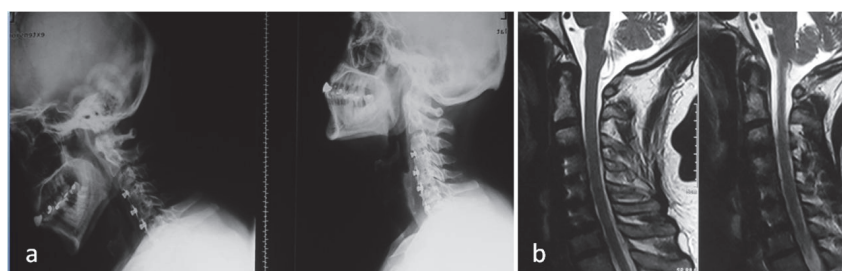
A 60 year-old male patient with 4-level ACDF with PEEK cages with perfect cervical spinal bony fusion on radiographs (a), and sagittal MR image that shows vertebral alignment and successful restoration of ventral subarachnoid space through the span of operated levels.
